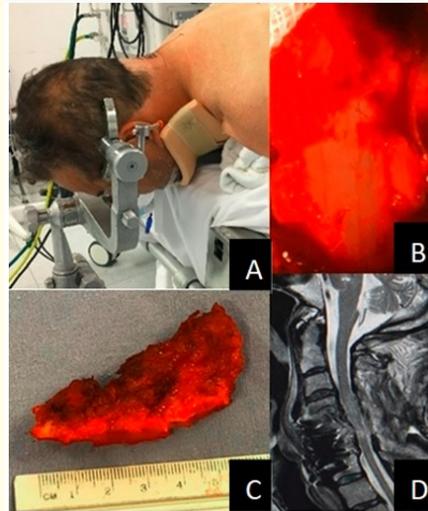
A) Patient positioning with Mayfield clamp, ventral position, no flex of cervical spine. B) Dural pulse view posterior of laminectomy. C) Photograph of cervical spine lamina and base spinous process. D) Postoperative MRI T2 sagittal view, mielopathic changes in C4-C6, hyperintensity of cervical spine levels due to corpectomy, increase of cervical spine canal in C3-C6.
